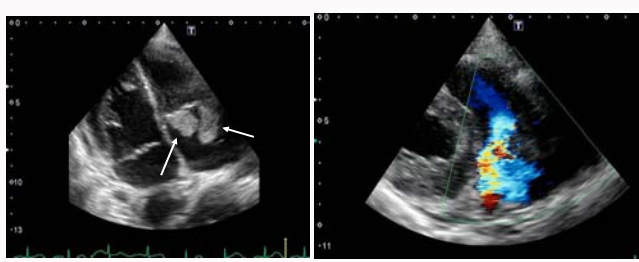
Transthoracic- echocardiogram showed two vegetations (white arrows) and severe TR.
